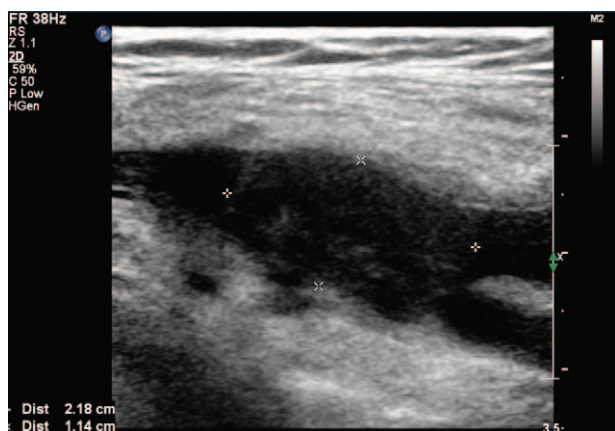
Sonography showed a hypoechoic mass (2.0 × 1.2 cm) in the right common femoral vein.
